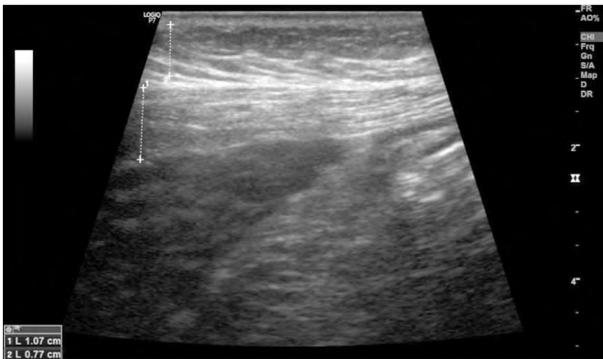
Showing AFI being measured using ultrasound.
